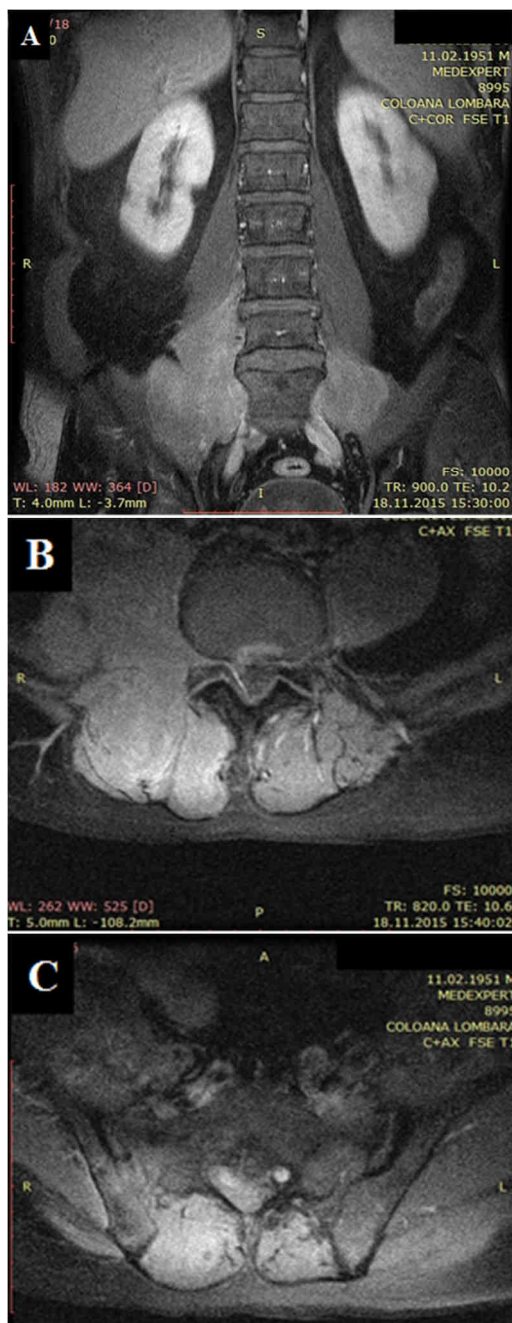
Lumbar spine MRI, T1 weighted images after contrast administration in coronal plane that show a bilateral dumbbell shaped hyper intense mass
